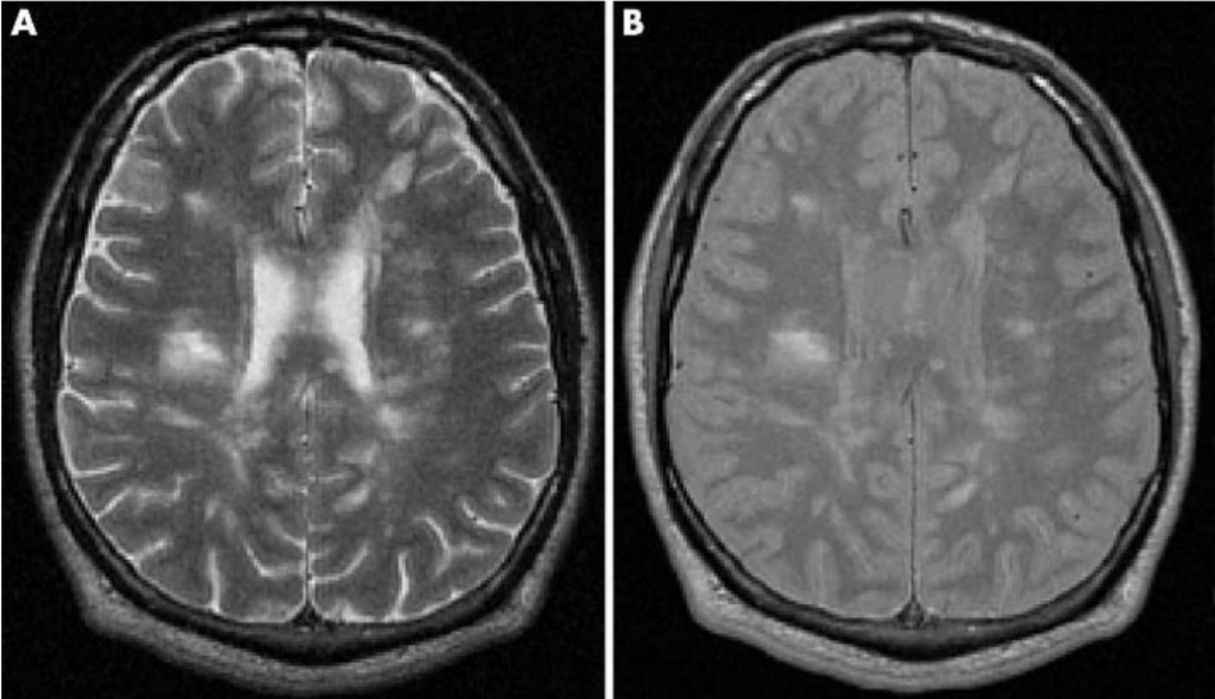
Axial MRI of a patient with Relapsing-Remitting Multiple sclerosis showing multiple dysmyelinating lesions.
